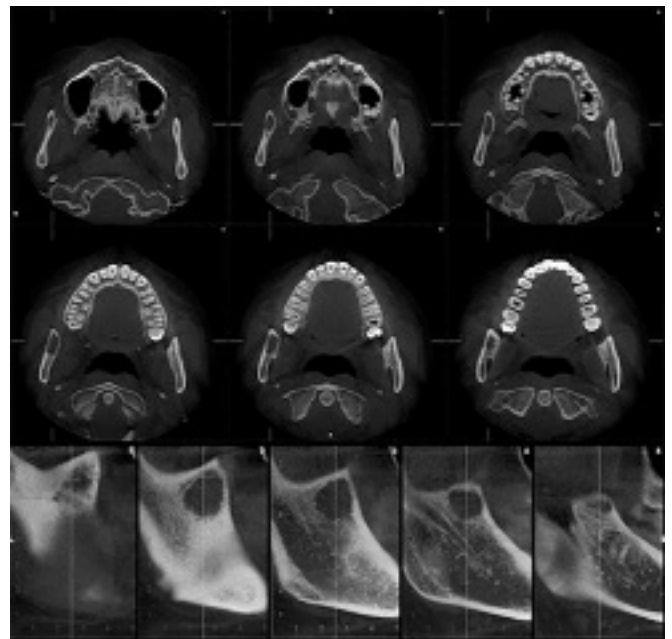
Cone beam computed tomography revealing a hypodense lesion.
